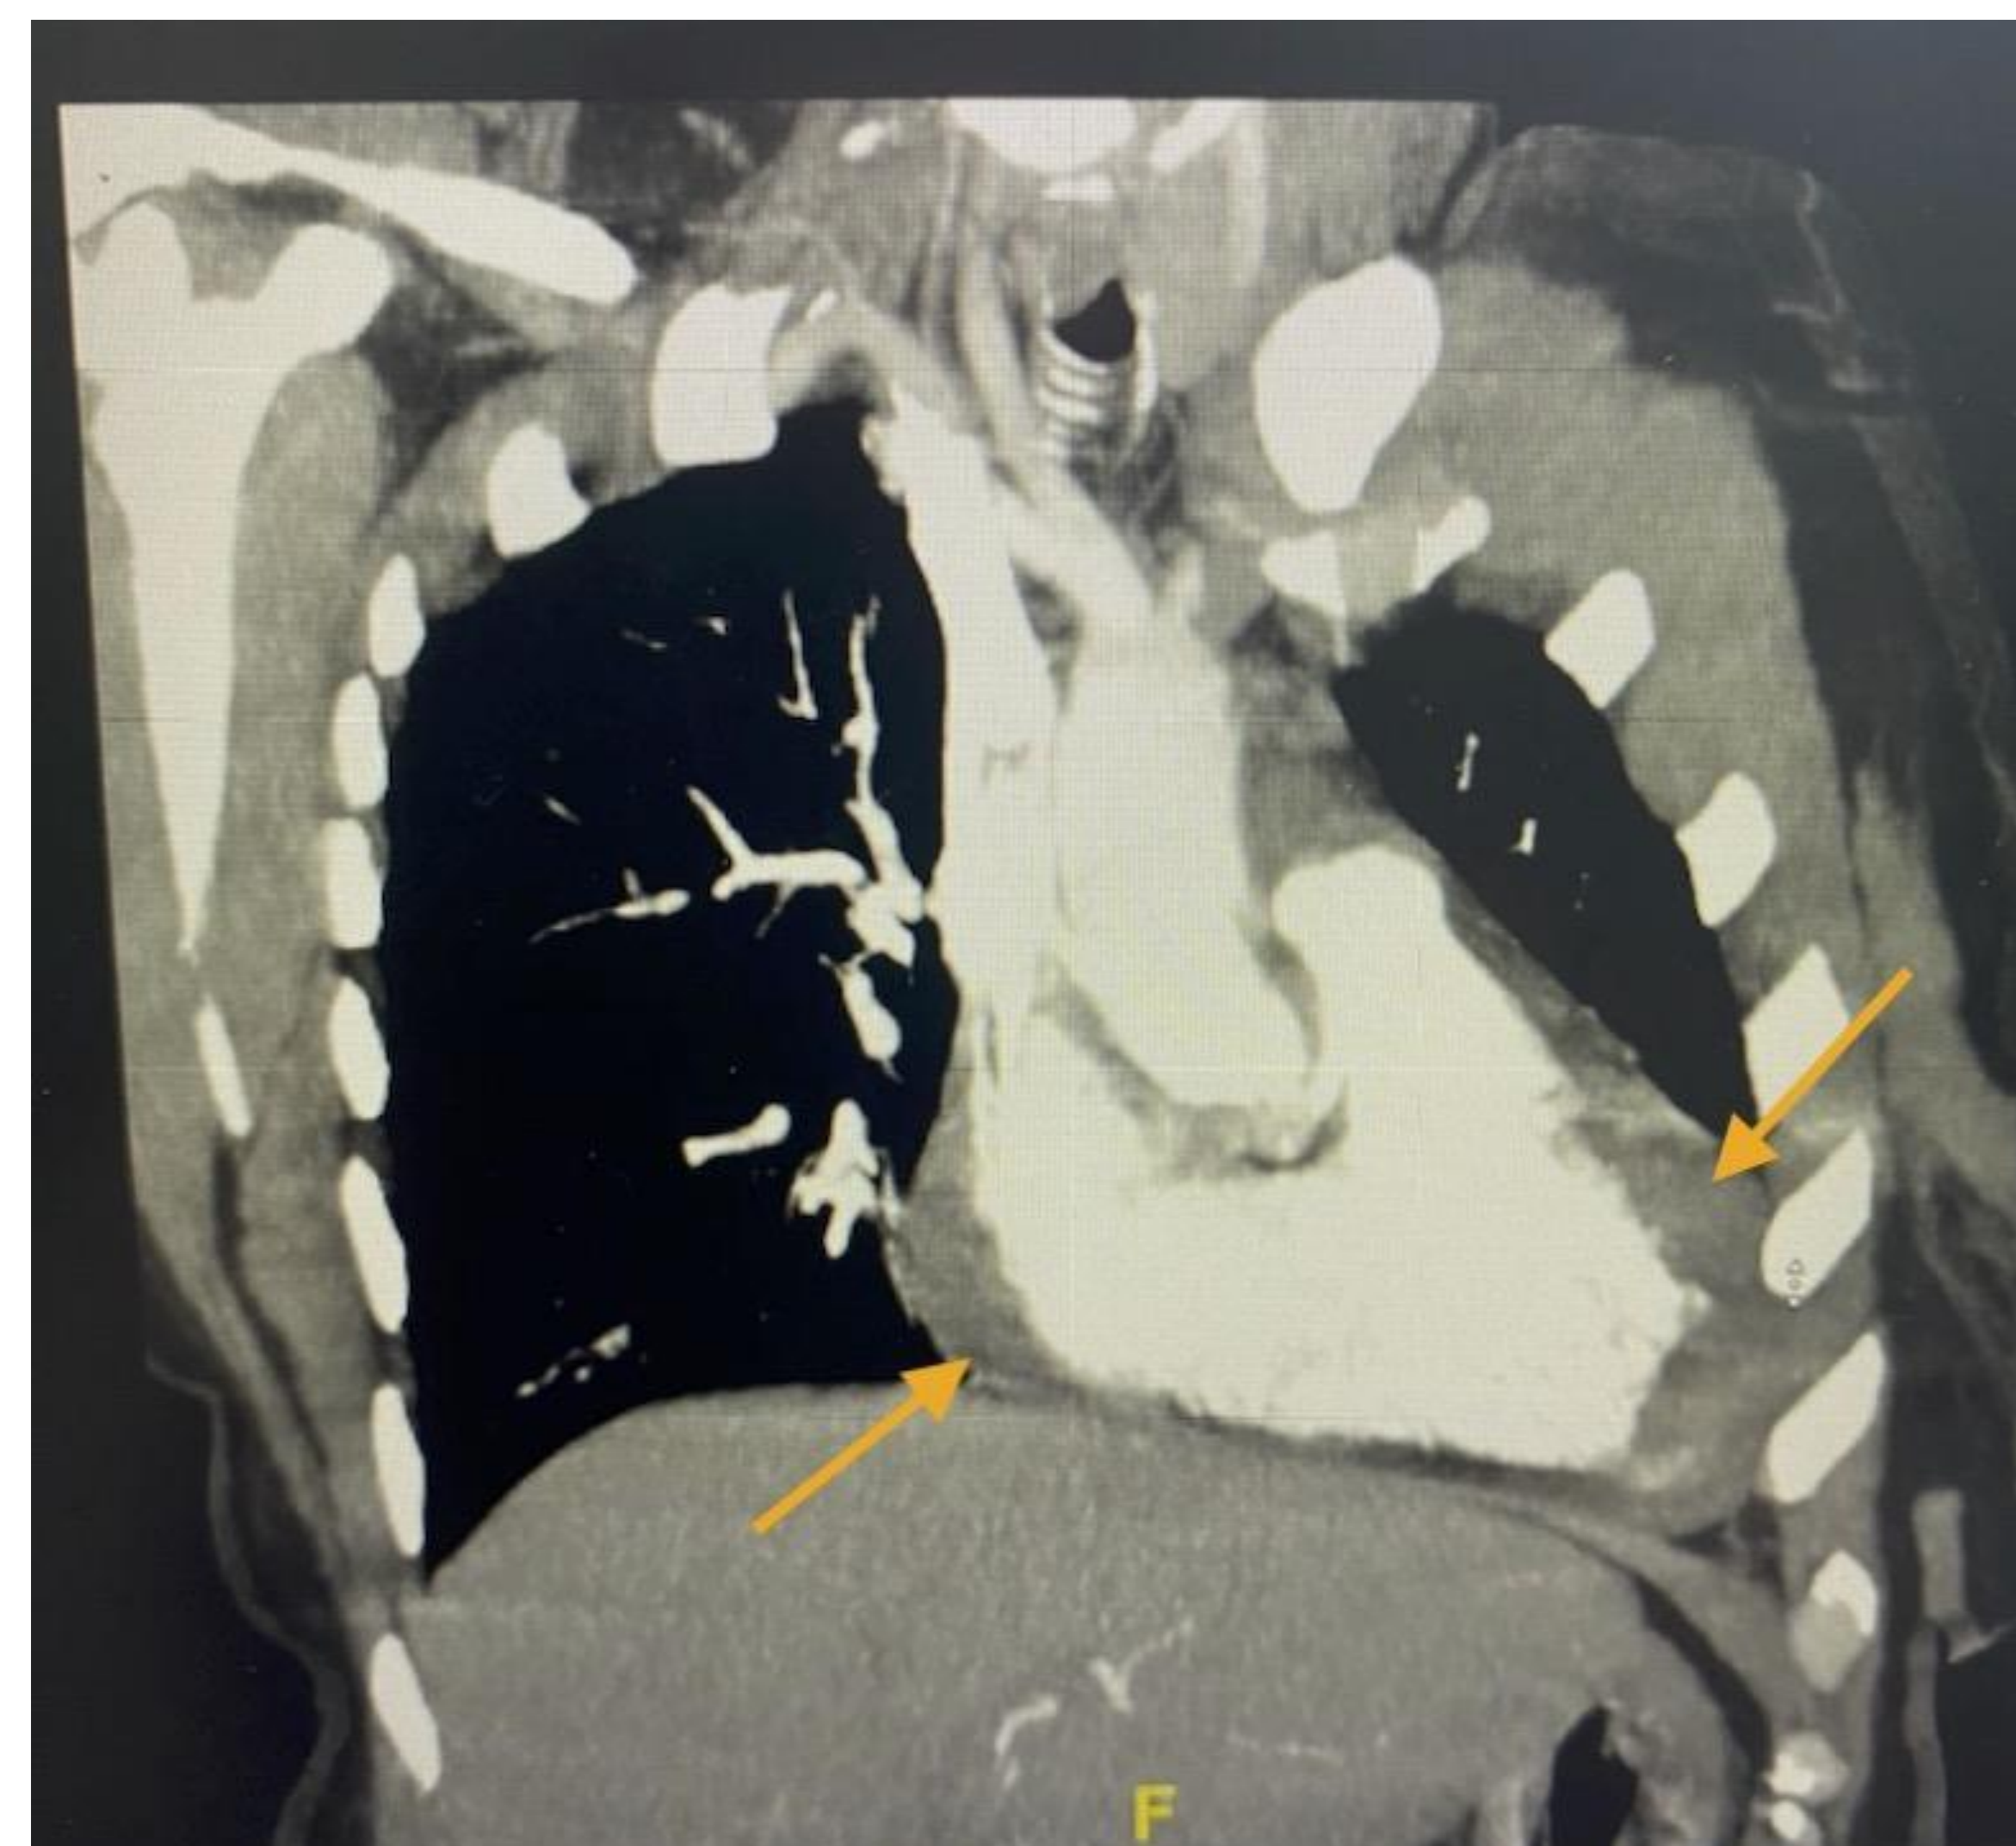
Chest CT (arrows) showing mild to moderate pericardial effusion
